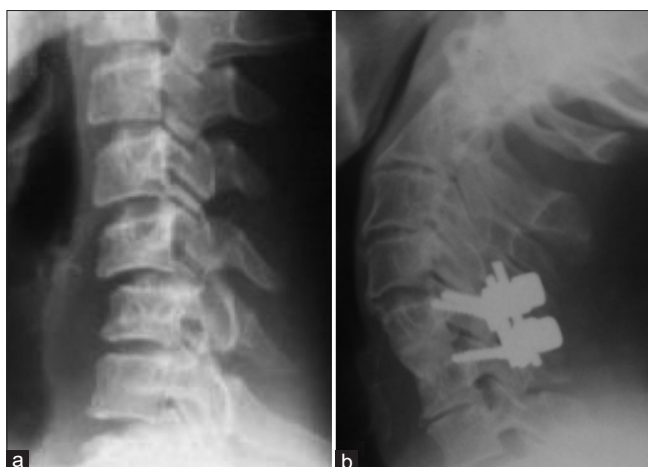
Radiographs of patient number 3. (a) X-ray showing unifacetal dislocation at C5–C6, (b) postoperative X-ray showing reduction of dislocation and fixation with lateral mass screws posteriorly and anterior cervical discectomy and fusion done anterorolt
